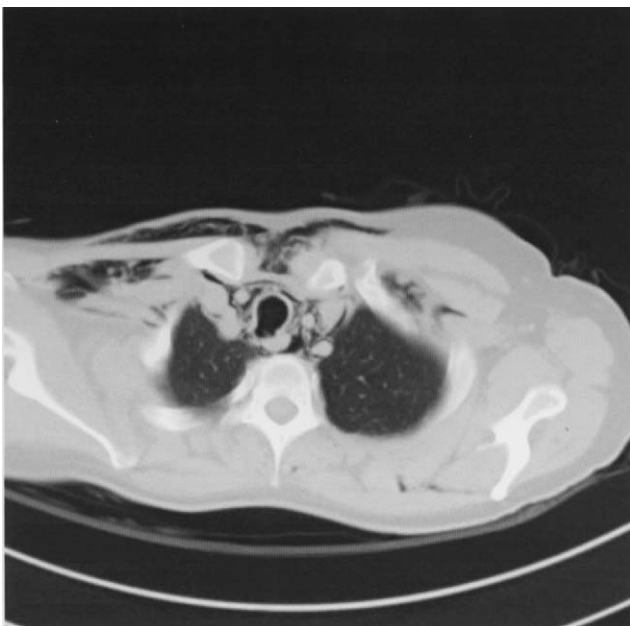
CT scan of a Level II postintubation tracheobronchial laceration.
